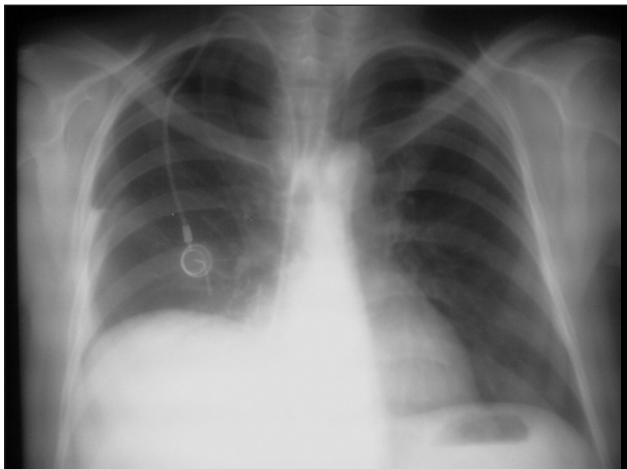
Chest radiography before total parenteral nutrition showing the central venous catheter at the right side, with its distal tip projected to the right atrium and right diaphragmatic cupule.
